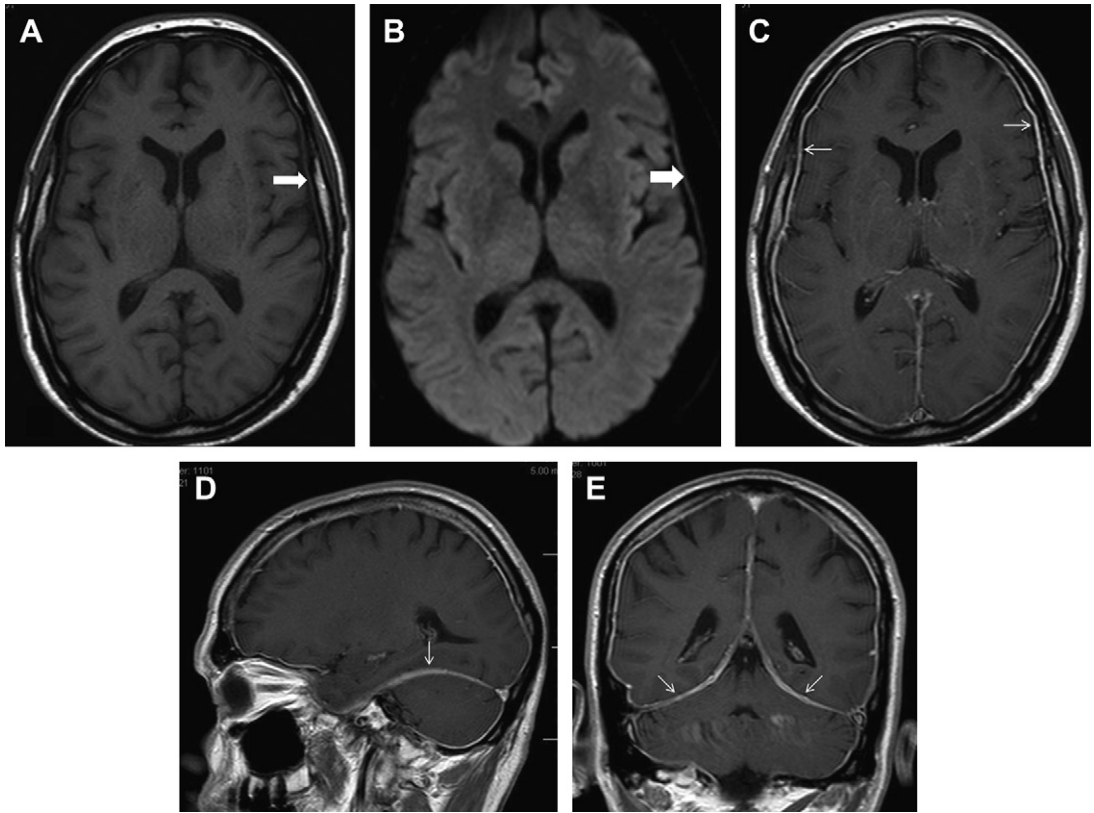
Idiopathic pachymeningitis in a 46-year-old man. Axial T1WI (A) and DWI (B) show minimal dural thickening (*white block arrows*), with intense diffuse enhancement (*white arrows*) on postcontrast axial, sagittal, and coronal T1WI (C–E).
